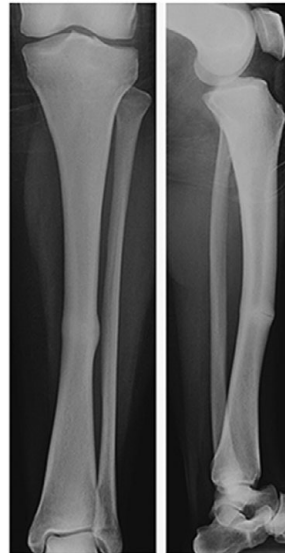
Anteroposterior (AP) and lateral radiographs left tibia demonstrating fracture
